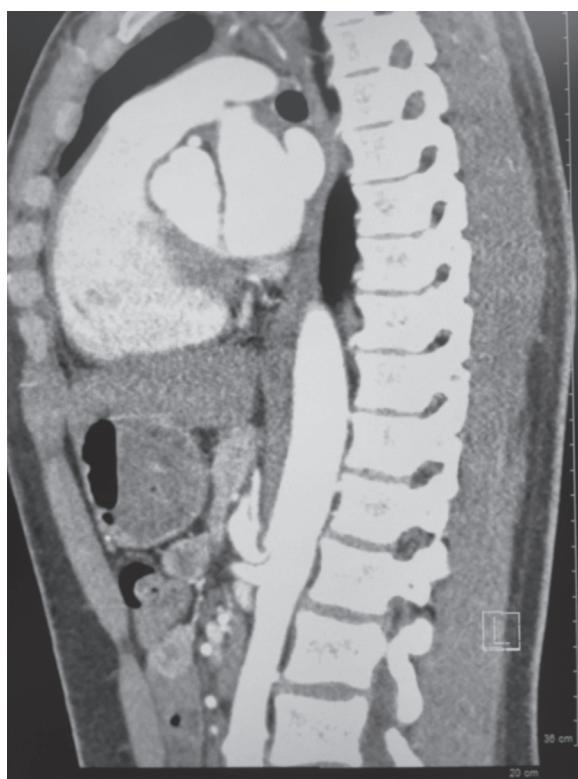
Sagittal view from a computed tomography angiography depicting celiac stenosis and poststenotic dilation due to median arcuate ligament compression.
